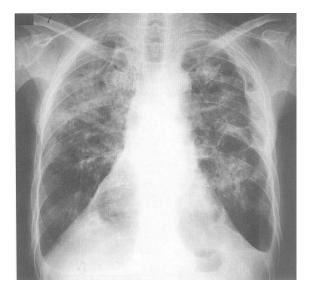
A chest X-ray after surgery and subsequent systemic chemotherapy showing disappearance of pleural effusion.
